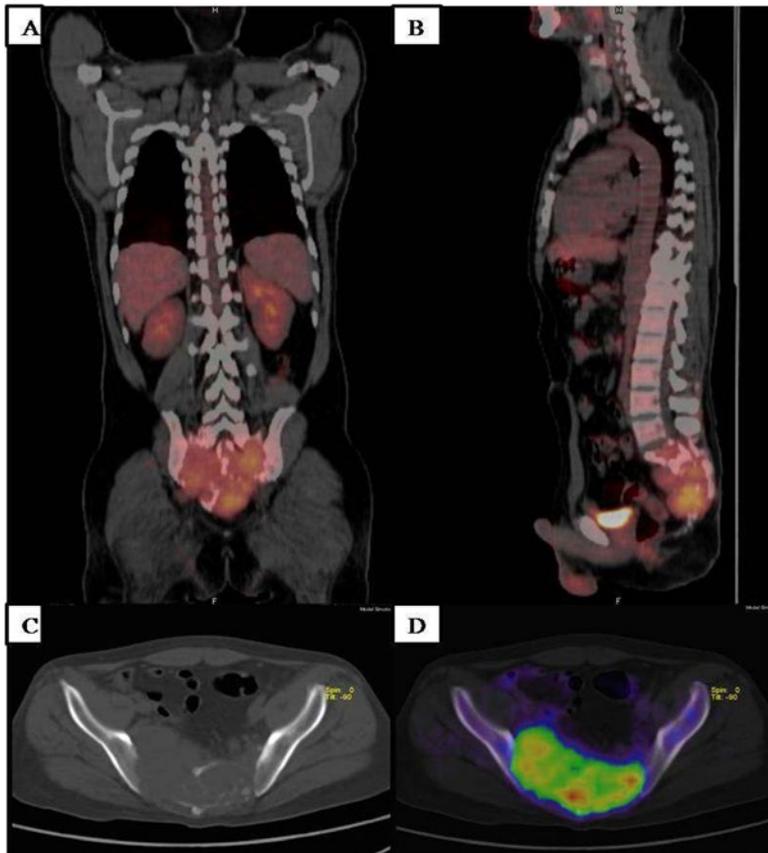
(A) & sagittal (B) image shows destructive lytic lesion involving sacrum and Rt iliac bone with associated soft tissue component (C), Transaxial NCCT (D) Fused PET/CT sagittal image at the same level depicts a region of hypermetabolic activity corresponding to biopsy-proven Ewing sarcoma.
